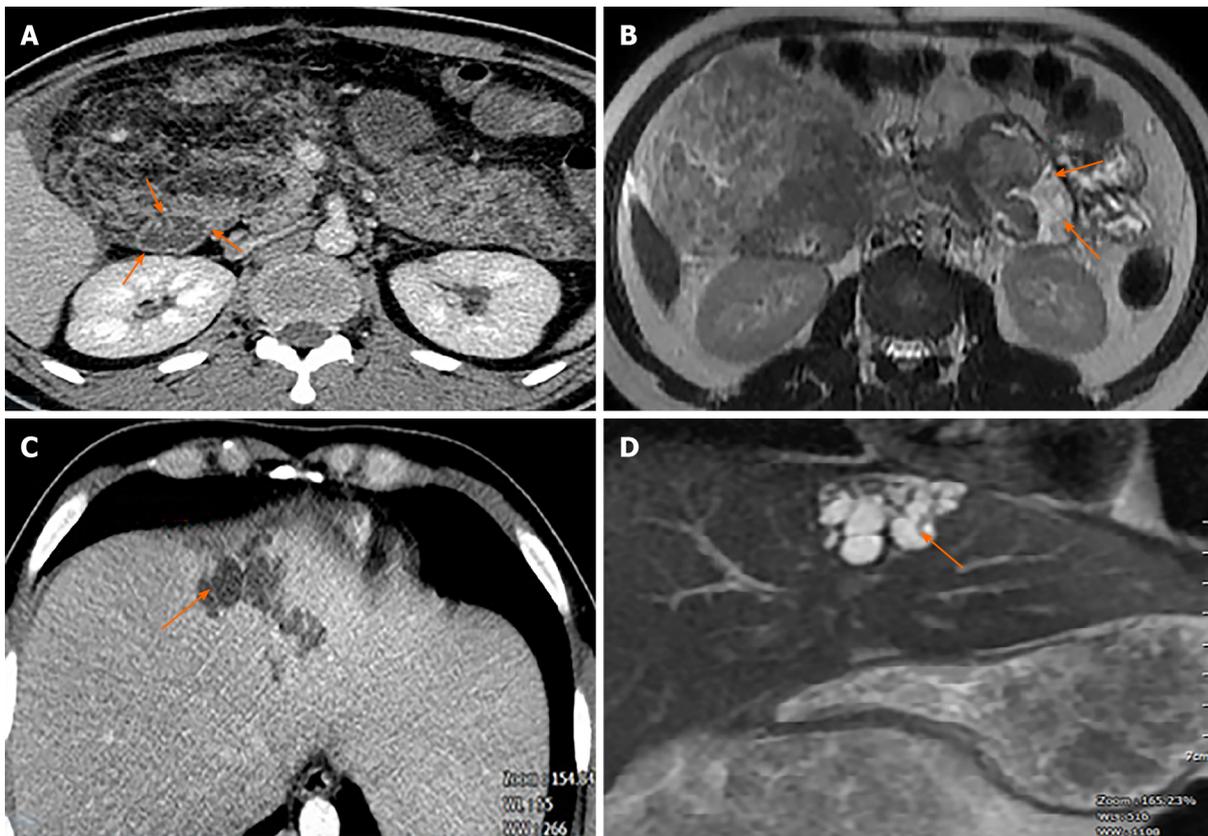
Contrast-enhanced computed tomography (CECT) and magnetic resonance imaging (MRI). A: CECT showing fatty tissue infiltration into duodenal wall (orange arrows); B: MRI also showed fatty tissue infiltration into duodenal wall (orange arrows); C: CECT scan showed hypoechoic saccular dilatations in segment IV of the liver; D: T2-weighted MRI showed segmental biliary ectasia (arrow).
